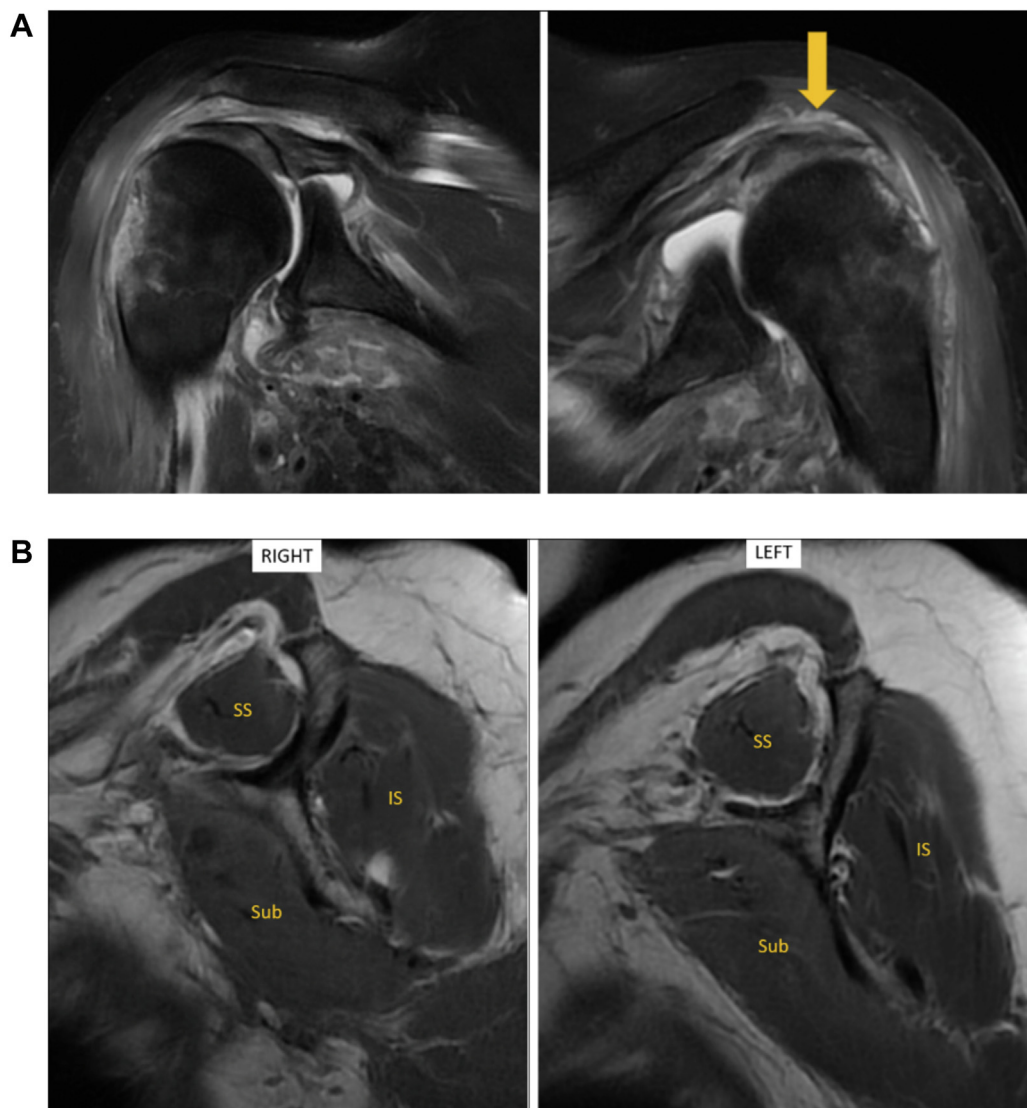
Preoperative MRI bilateral shoulders. (A) Coronal T2 sequence demonstrating intact rotator cuff tendons and displacement of tuberosity fragments, with increased displacement of left greater tuberosity compared to postreduction radiographs (→). (B) Minimal fatty infiltration is present on sagittal T1 images of the rotator cuff muscles (SS, supraspinatus; IS, infraspinatus; Sub, subscapularis).
